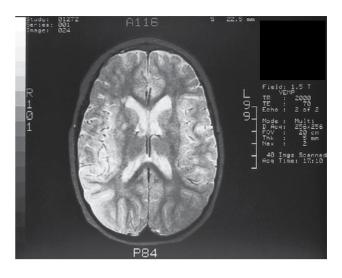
MRI of CH, a patient with methylmalonyl CoA mutase deficiency. There was a diffuse pattern of abnormal signal intensity in the cerebral hemispheres and focal areas of abnormal signal in the basal ganglia.
